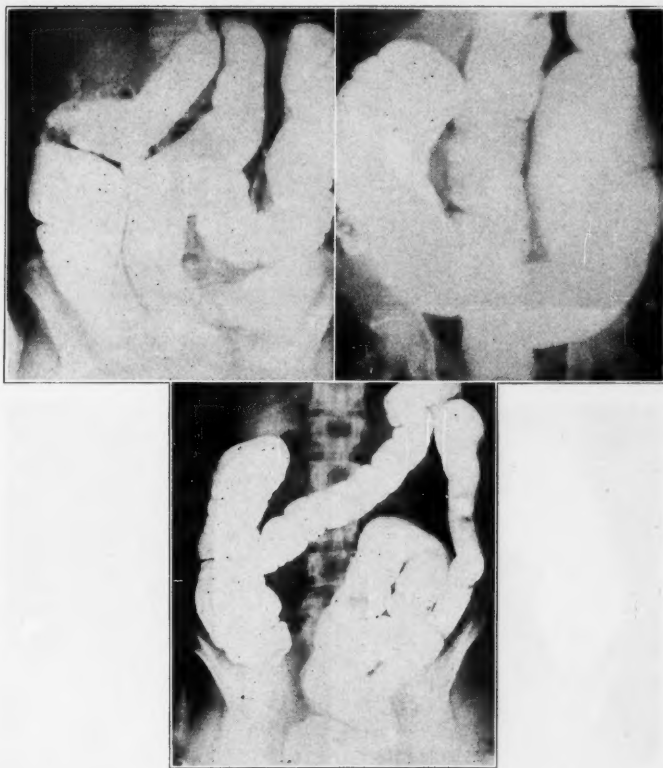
Roentgenograms showing varying degrees of redundant sigmoid.
